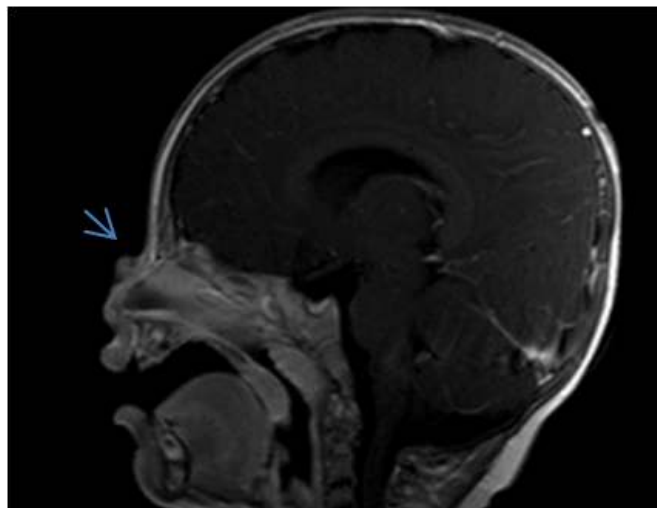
Magnetic resonance imaging showing an enhancing soft tissue mass without intracranial extension on the nasal bridge (arrow)
